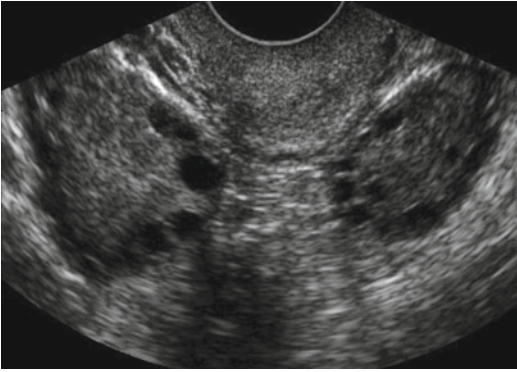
AFC of PCOS ovary in 2D ultrasound
